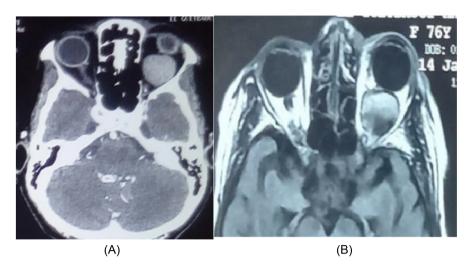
CT scan (A) and Axial T1-weighted (B), show an Orbital Cavernous Hemangioma.
